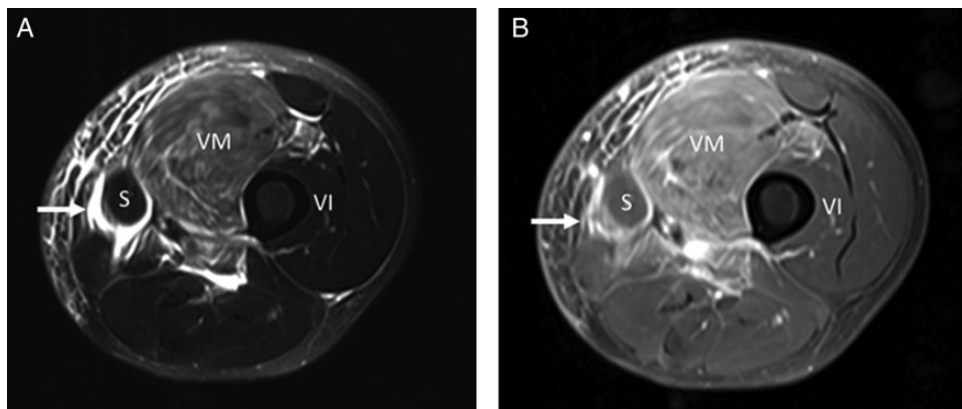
Axial T2 (A) and T1-weighted (B) images with fat saturation through the left mid-thigh after intravenous gadolinium administration demonstrate edema and enhancement in the anteromedial thigh musculature, with a swollen and edematous vastus medialis (VM) muscle. High T2 signal and enhancement also tracks along the interfascial planes, most marked around the sartorius muscle (S) (arrows).
